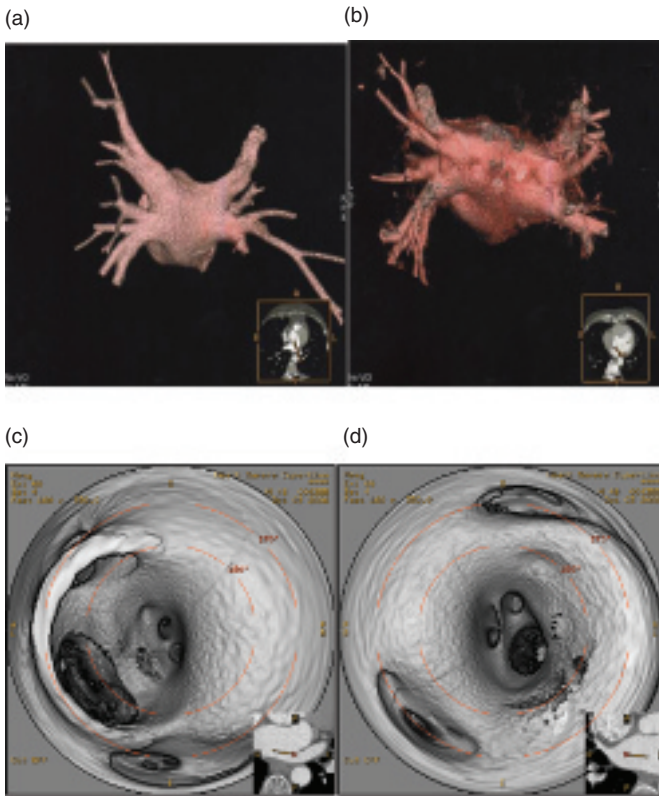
(Top panel) CT angio of the left atrium of two different patients showing variance of pulmonary vein anatomy. Panels (c) and (d) show a fly-through of the left atrium and pulmonary vein of first patient.
